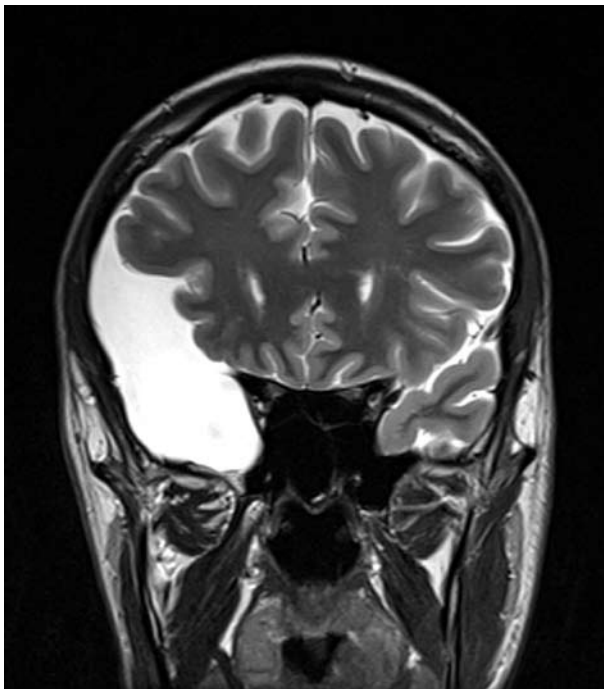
T3-weighted magnetic resonance image (coronal plane) showing a large oval mass.
